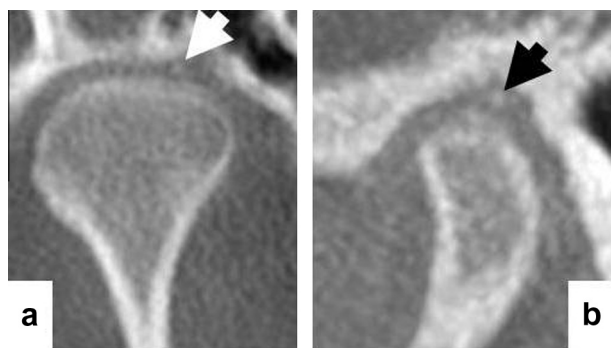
Corrected coronal (a) and sagittal (b) CBCT sectional images (maximum intensity projections, 2 mm in thickness) showing examples of radiopacities (marked by arrows) diagnosed as soft tissue calcification because they were more radiopaque than the surrounding image noise pattern.
